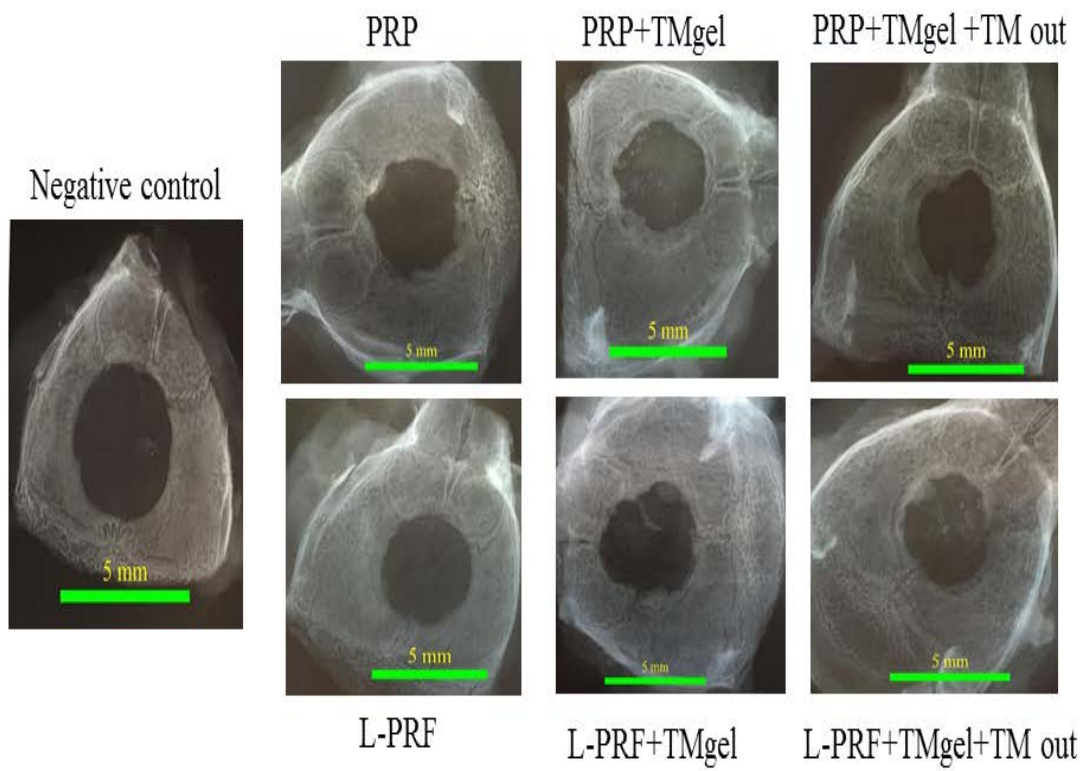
Representative radiographs.
